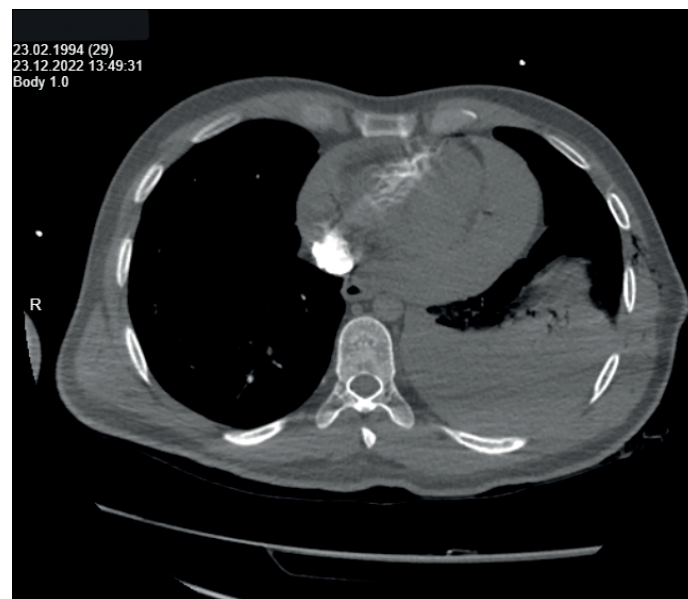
Computed Tomography image upon admission with injury
